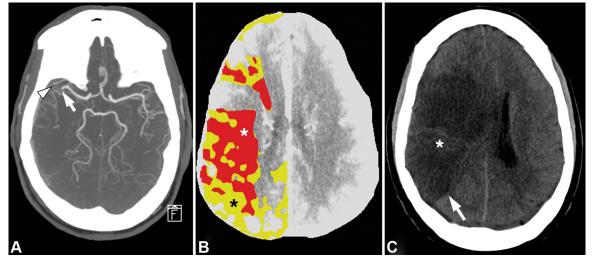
A 58-year-old man with a history of heart failure and asthma developed new left-sided weakness while hospitalized for COVID-19 pneumonia, sepsis, and acute kidney injury. A. A head CT angiography (CTA) demonstrates a superior M2 branch cut off (arrowhead) and an inferior M2 branch cut off (arrow) of the right middle cerebral artery. B. CT Perfusion (CTP) shows a core infarct (white asterisk) and surrounding penumbra (black asterisk) in the right middle cerebral artery distribution. The patient was taken to interventional neuroradiology for mechanical thrombectomy with incomplete recanalization. C. Several days later, the follow-up head CT demonstrates evolution of the infarct with loss of gray–white differentiation and edema (*arrow*). Linear hyperdensity may reflect petechial hemorrhage (asterisk). CT, computed tomography.
